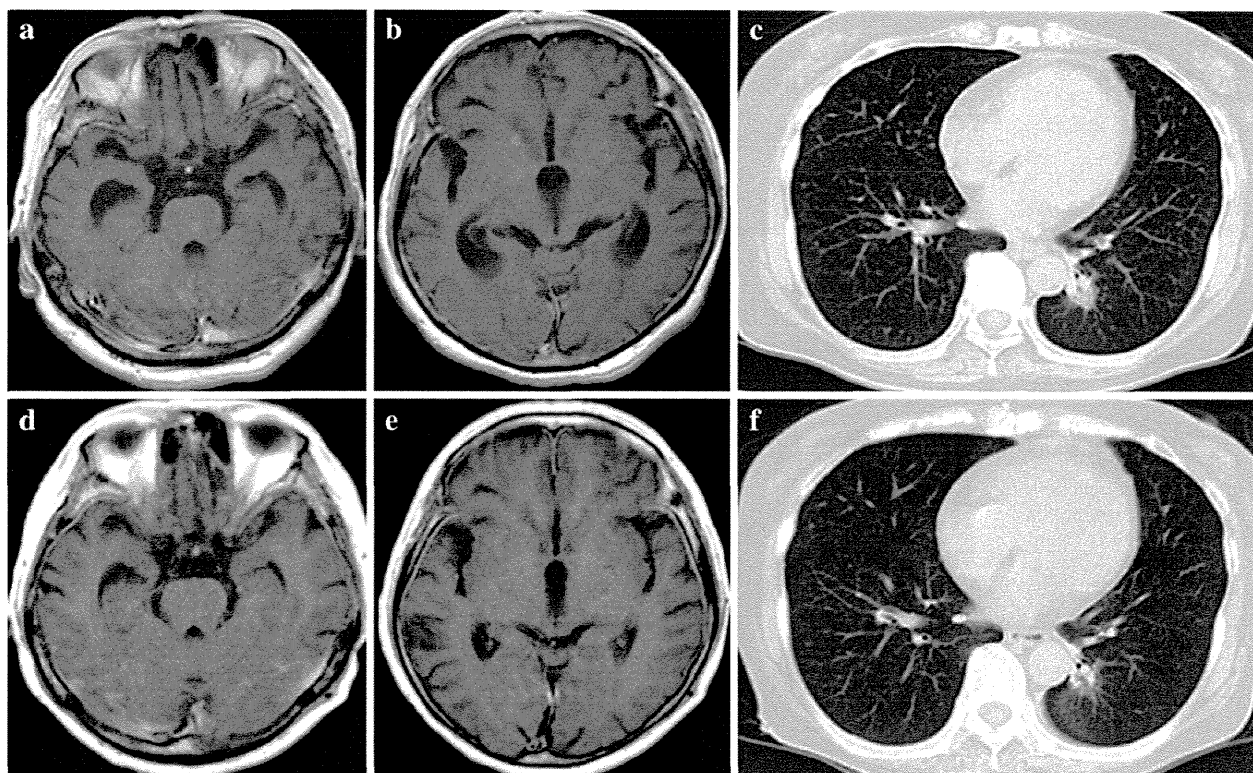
Imaging studies pre- and post-gefitinib treatment. a, b T1-weighted gadolinium-enhanced MRI of the head reveals multiple small enhanced lesions. c Chest CT shows a mass-like lesion in the left lung S6 with diffuse granular shadows. d, e T1-weighted
